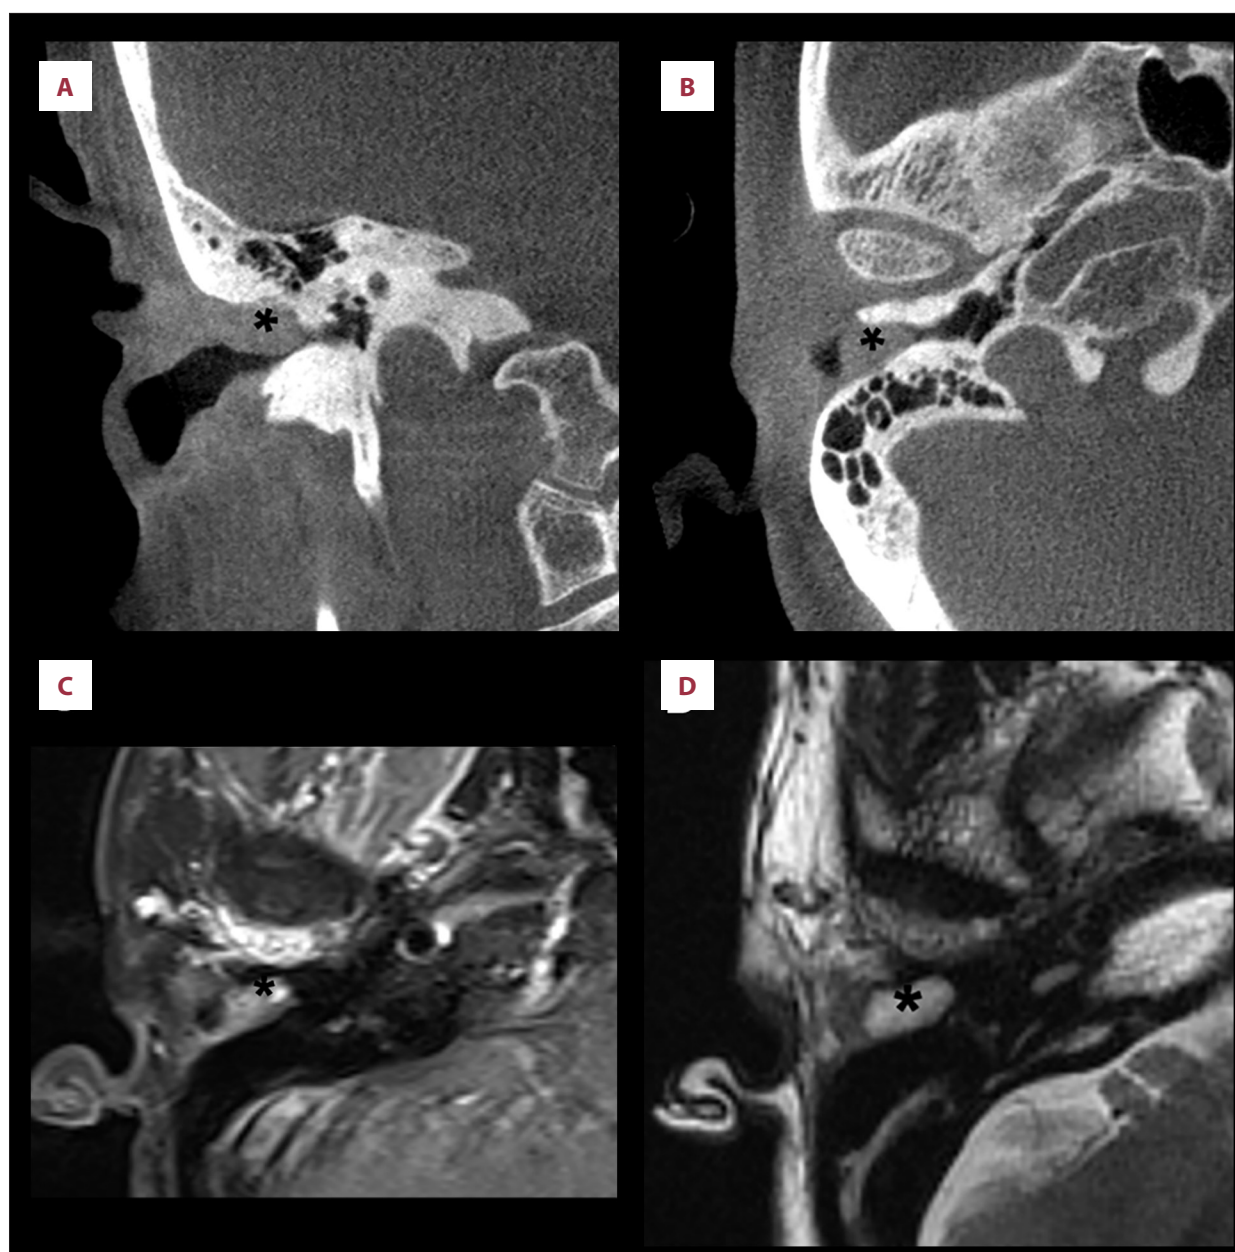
CT and MRI images in Case 2. (A, B) CT showing soft-tissue masses in the right EAC with a marked narrowing of the canal and suspected erosion of the bony wall in the superior aspect. (C, D) T1-weighted and T2-weighted MRI showed an oval nodule in the bony portion of the right EAC. The asterisk indicates the tumor. CT, computed tomography; MRI, magnetic resonance imaging; EAC, external auditory canal.
